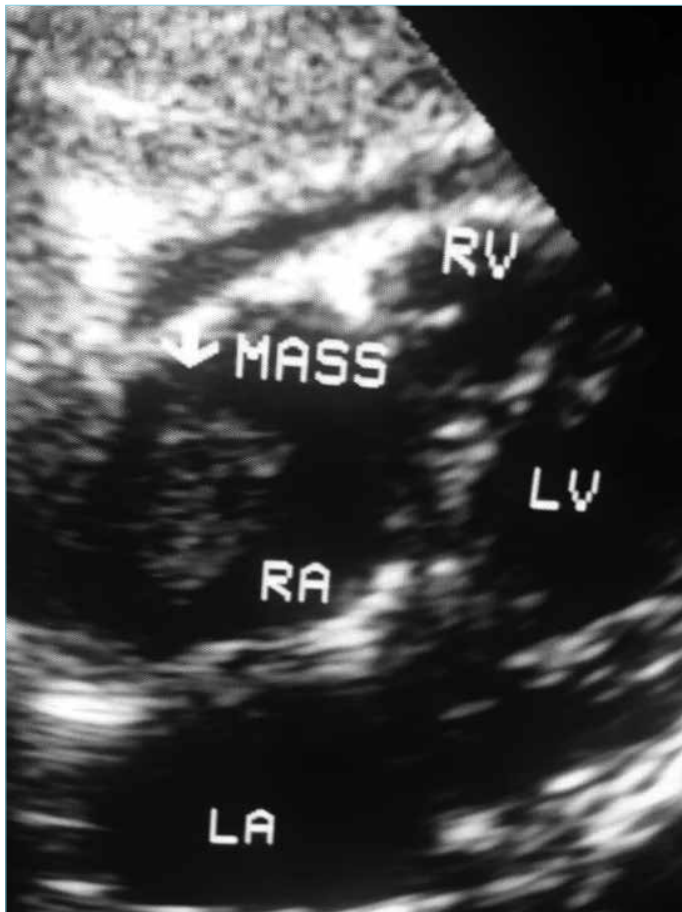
Echocardiography suggestive of a mass in right atrium extending from IVC likely to be a thrombus with dilated right sided chambers
